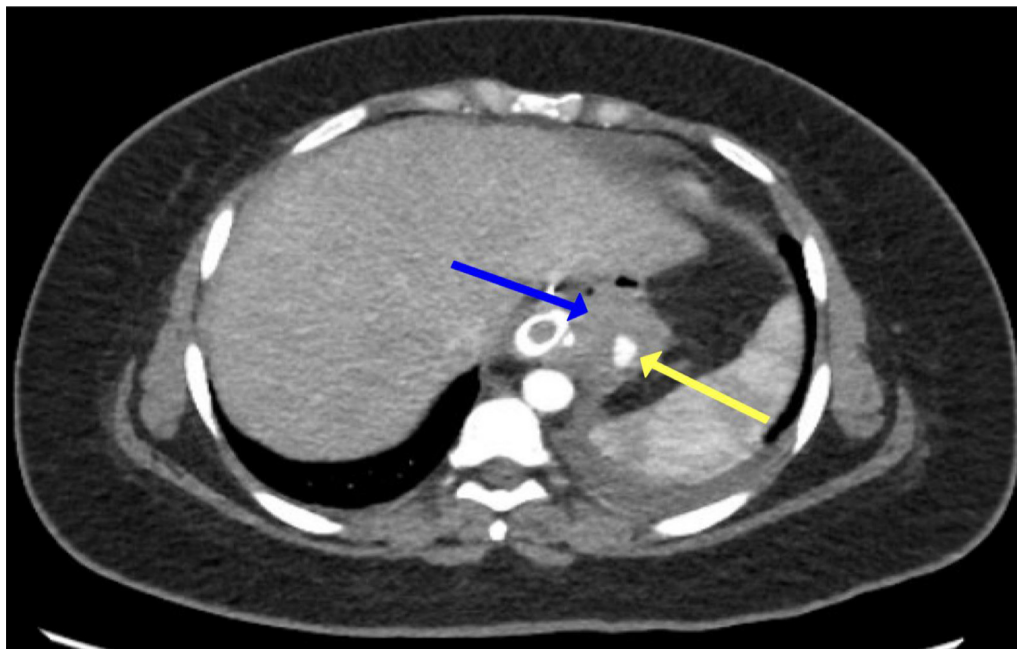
An axial image of contrast-enhanced abdomen CT with arterial phase at the diaphragm level shows a focal contrast blush in the arterial phase (yellow arrow) measuring 1.1 cm (AP) x 1.7 cm (W) surrounded by a hematoma (blue arrow) measuring 4 cm (AP) x 4.7 cm (W), indicating a pseudoaneurysm.
